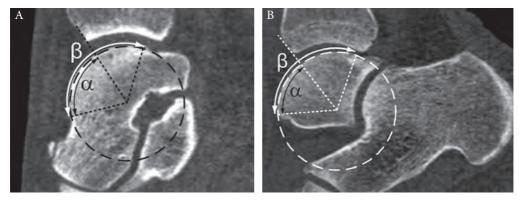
Sagittal computed tomography reconstructions of a fully plantarflexed ankle showing the measurements performed to assess the arthroscopic reach of the medial (A) and lateral (B) talar domes. Using a custom-made software routine, a circle was fit through the talar articular surface. Angle α (black arrow, i.e., area anterior to the distal tibial rim) was defined by the arc length of the circle between the dashed lines from the midpoint of the circle to the anterior border of the talar dome and to the anterior distal tibial rim, respectively, divided by the total circle's circumference. Angle β (white arrow, i.e., complete talar dome) was defined by the arc length of the circle between the dashed lines from the midpoint to the anterior border of the talar dome and to the posterior border of the talar dome, respectively, divided by the total circle's circumference. The arthroscopic reach (%) was calculated by dividing angle α by angle β times 100%.
